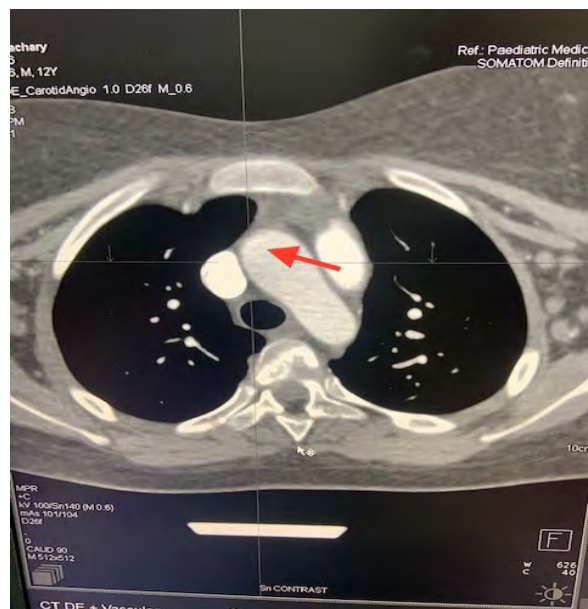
CT chest angiogram demonstrating hypo densities seen in intimal wall of the aortic arch.
